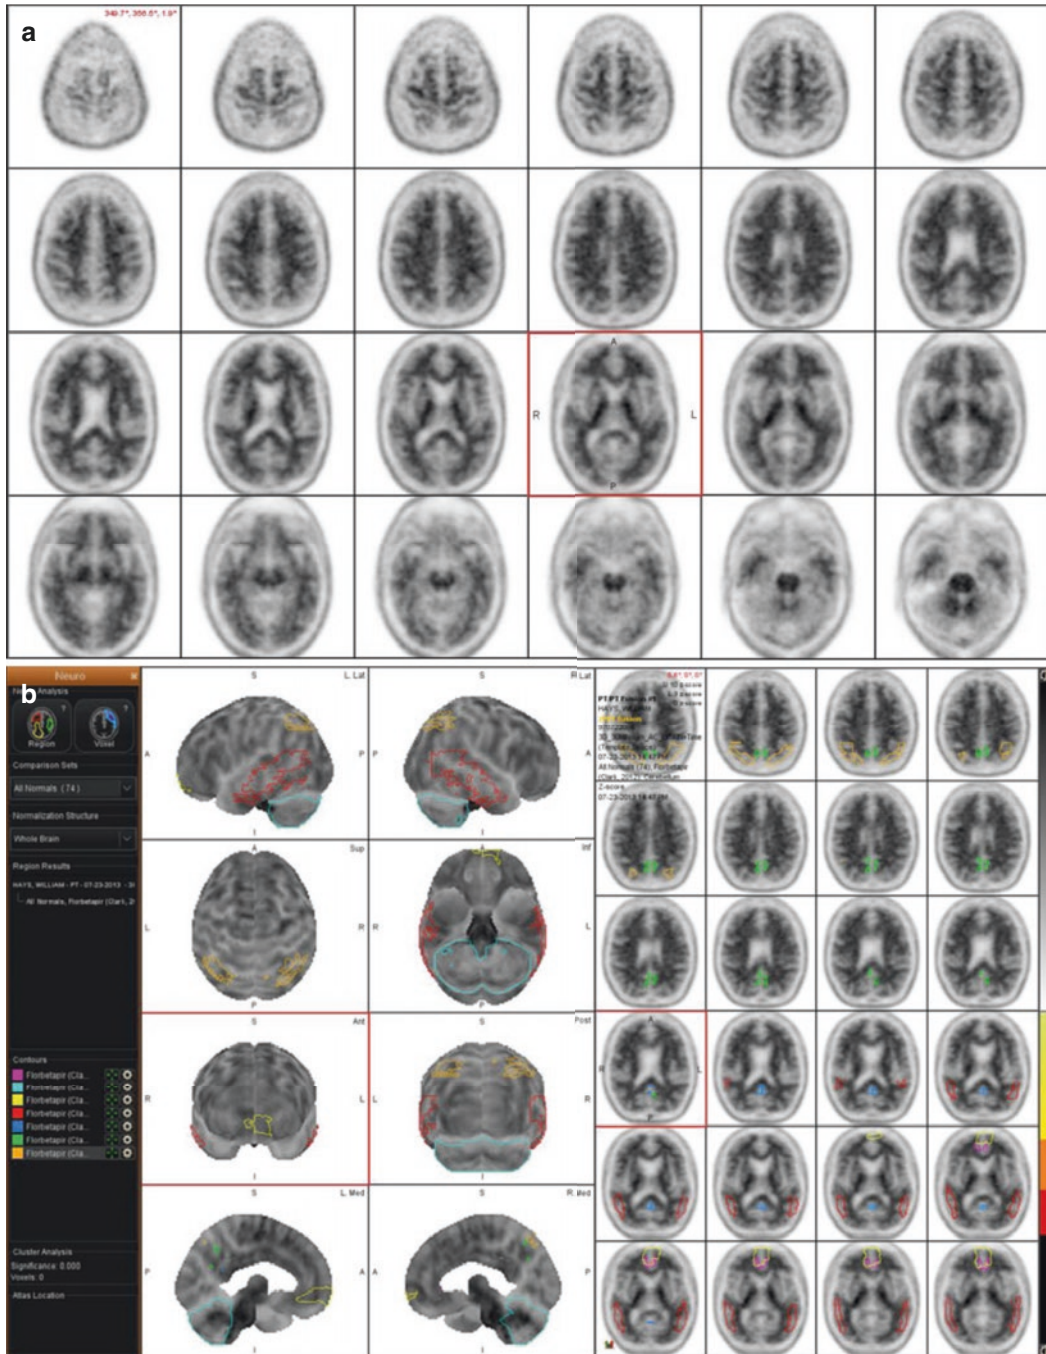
Negative AMYViD scan: (a) Cross-sectional images of 42-year-old male with cognitive decline. This scan is being performed to assess for amyloid plaques. After injection of 10 mCi of AMYViD IV, a brain PET scan was performed at 30 min on the GE VCT PET/CT scanner. Visually, contrast uptake is less intense in the gray matter and more intense in the white matter, and none of the areas that are typically seen to be involved with Alzheimer’s disease are identified as having statistically significantly abnormal amounts of uptake relative to
